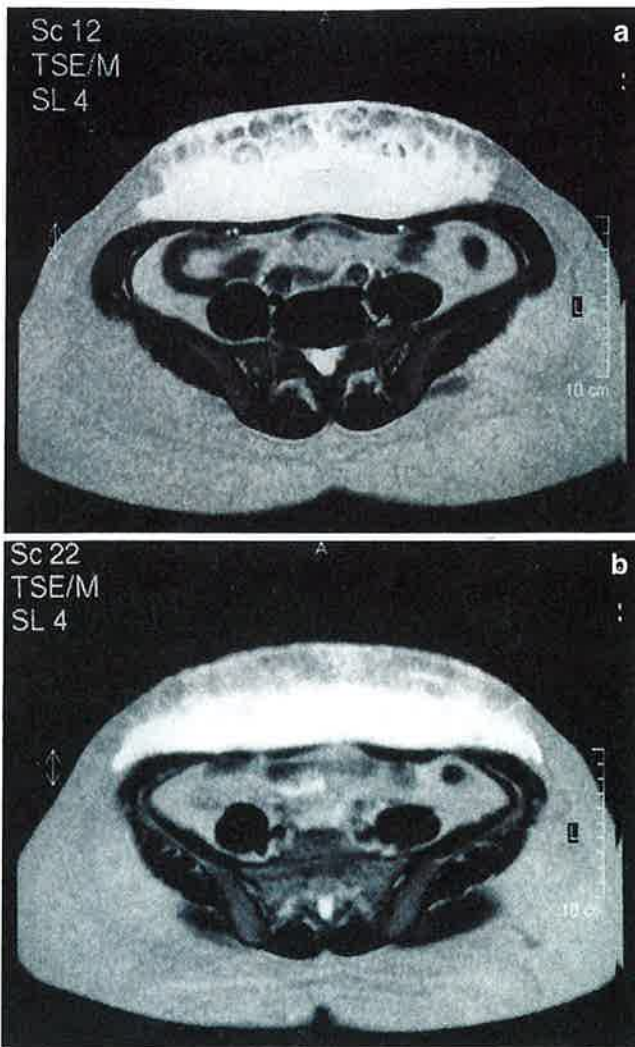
MRI T2 sequence comparison. (a) Pretreatment MRI depicting fat characterized by defined septae borders. (b) Six minutes following laser therapy at 635 nm revealing fat homogeneity and coalescence of tissue
